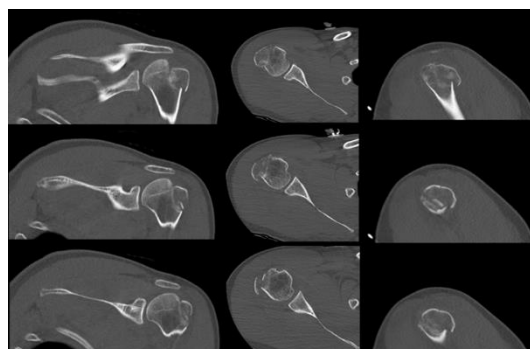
CT imaging of the right shoulder showing a comminuted displaced greater tuberosity fracture. The fracture showed inferior and posterior positioning, with mild extension into articular surface
